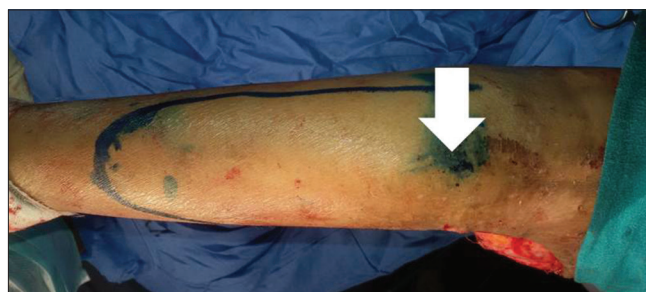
Marking of perforator plus flap design showing anterior tibial artery perforator located through hand-held Doppler device (white arrow)
